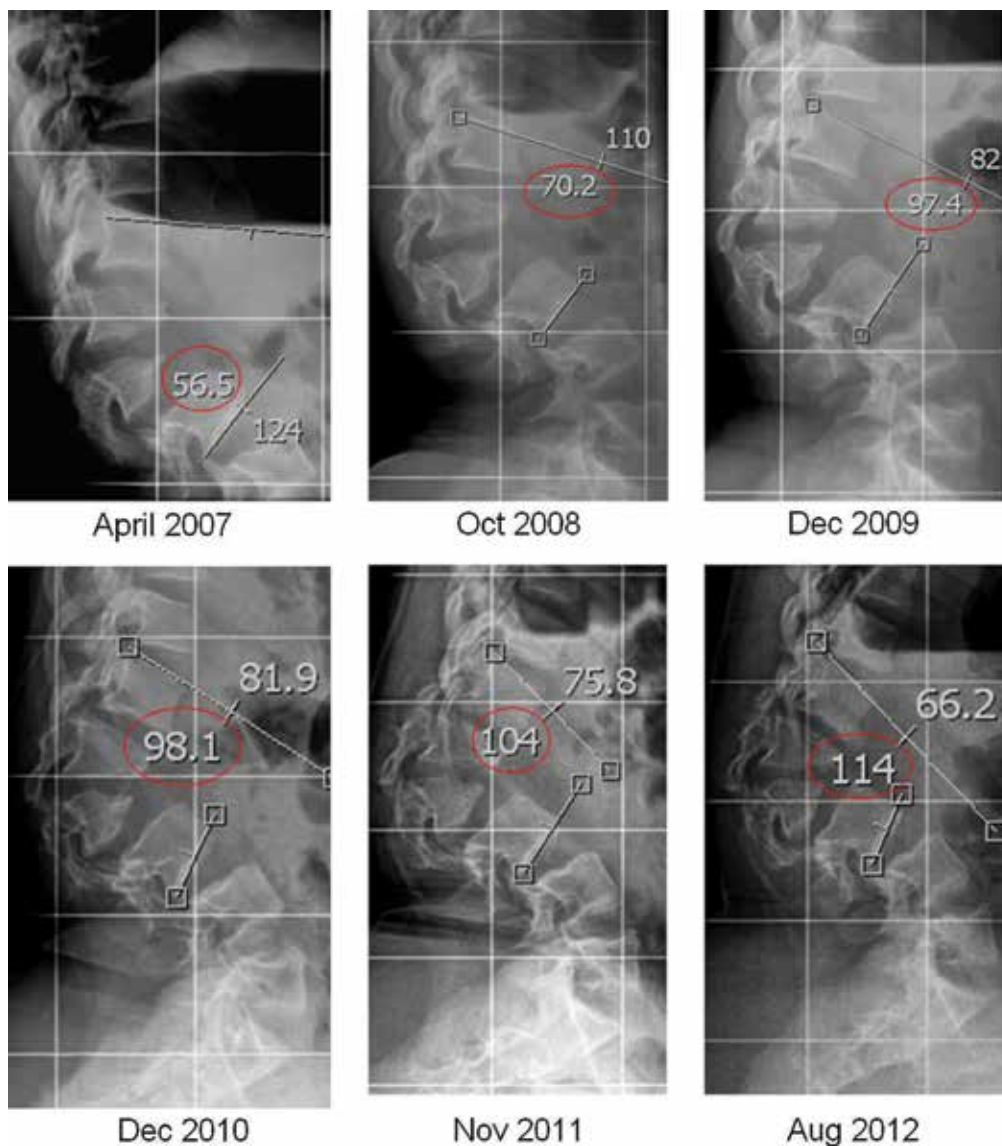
Case 1: coned lateral thoraco-lumbar X-rays.
